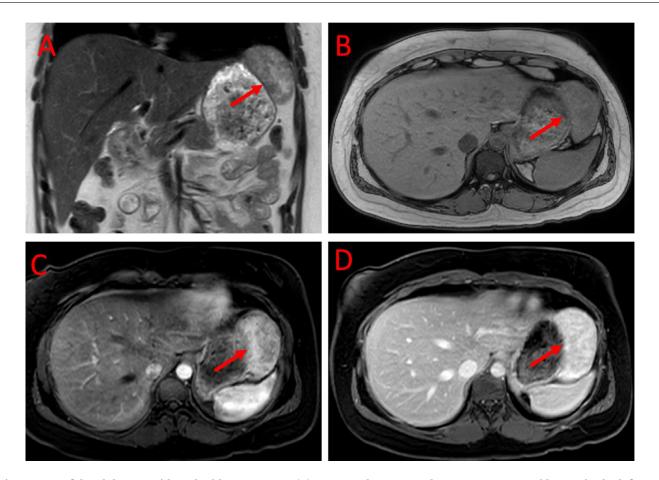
MRI of the abdomen with and without contrast. (A) T2 coronal sequence demonstrates an ovoid mass in the left upper quadrant with heterogenous T2 hyperintensity. (B) The opposed-phase axial sequence demonstrates no drop of the signal within the mass to suggest the presence of intralesional fat. (C) T1 axial fat-saturated sequence in the arterial phase demonstrates brisk heterogeneous enhancement, hyperintense to the liver, and hypointense to the adjacent spleen. (D) The delayed post-contrast sequence demonstrates persistent hyperintensity to the liver
